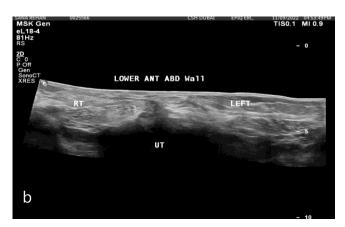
(a & b): Post-medical management ultrasound.
